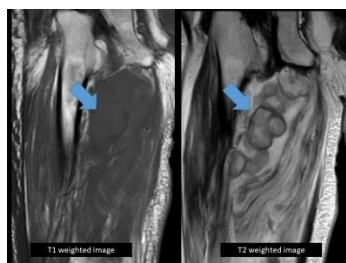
Magnetic resonance imaging (MRI) findings for the present case. MRI revealed low intensity on T1-weighted imaging and high intensity on T2-weighted imaging, suggesting abscess formation in the right leg (arrow)
